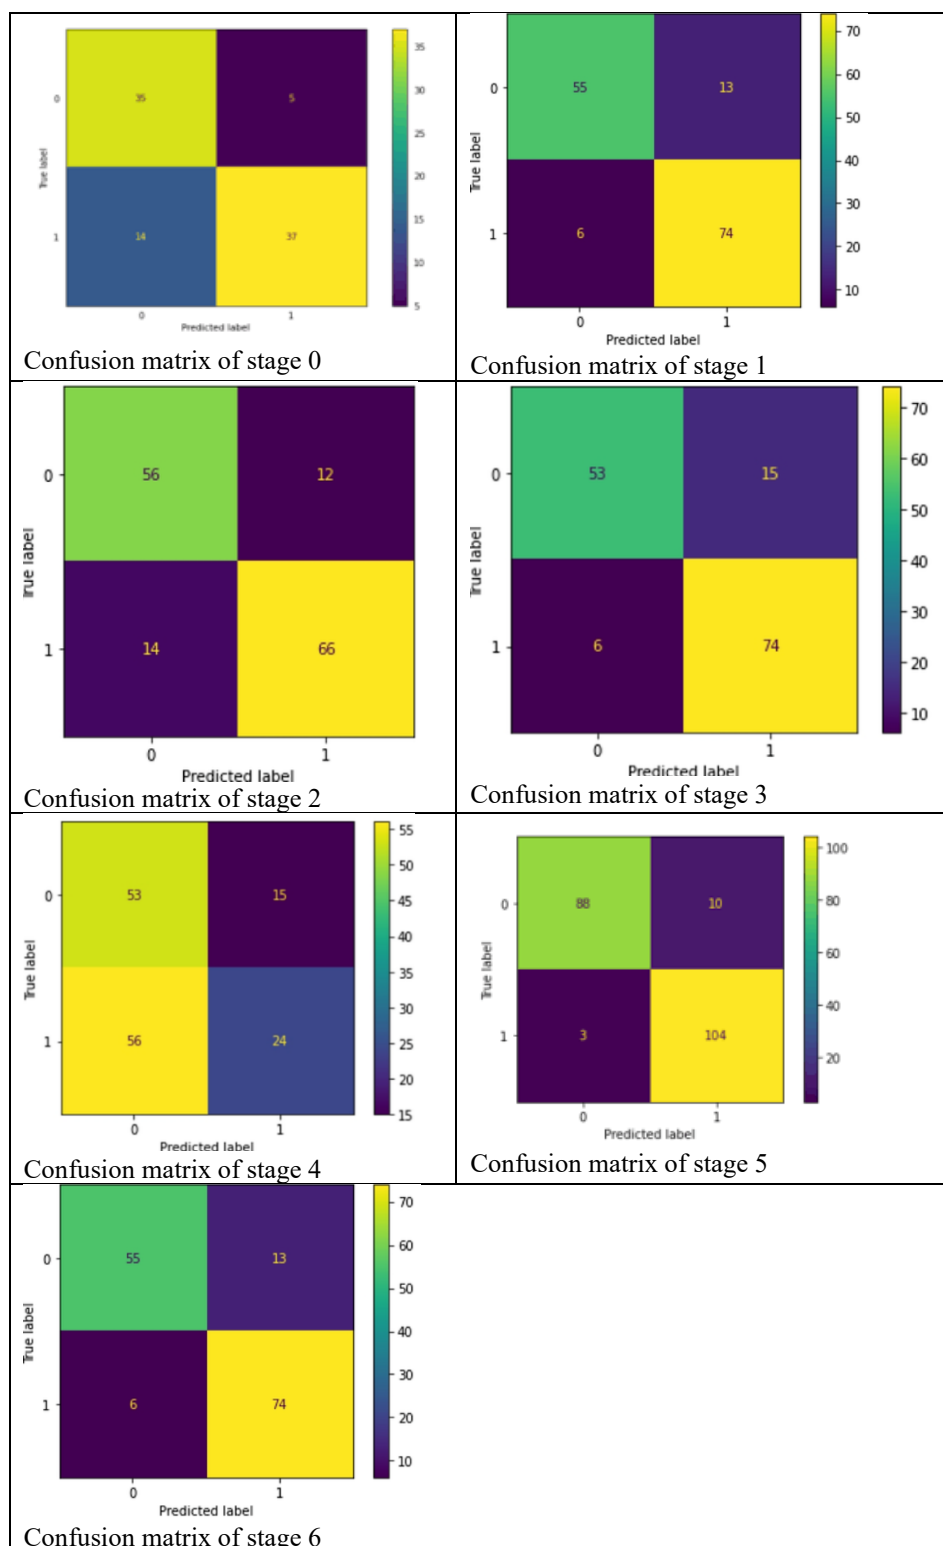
Confusion Matrix for Proposed MRI image dataset in stroke detection (a) stage 0 (b) stage 1, (c) stage 2, (d) stage 3, (e) stage 4, (f) stage 5, (g) stage 6
